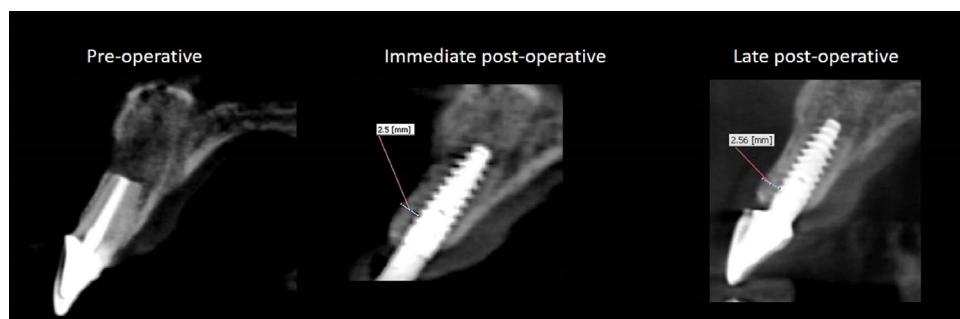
(A) CBCT: the preoperative cross-section shows a root after apicoectomy; a thin buccal crest is still present. (B) CBCT: immediately postoperative cross-section; a clear, thickened, buccal bone crest can be observed. (C) CBCT: late postoperative cross-section; hard-tissue remodelling was performed at the buccal crest after incorporation of the bone substitute material.
